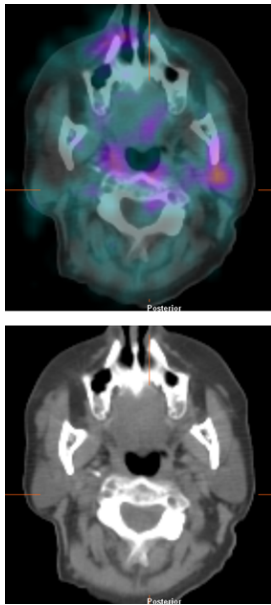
An example of a patient with uptake levels in left parotid gland higher than population mean $+3SD$. This patient had signs of xerostomia but no symptoms nor autoantibodies. The rheumatologist asked for a salivary gland scintigraphy that showed mild impairment of parotid function.
